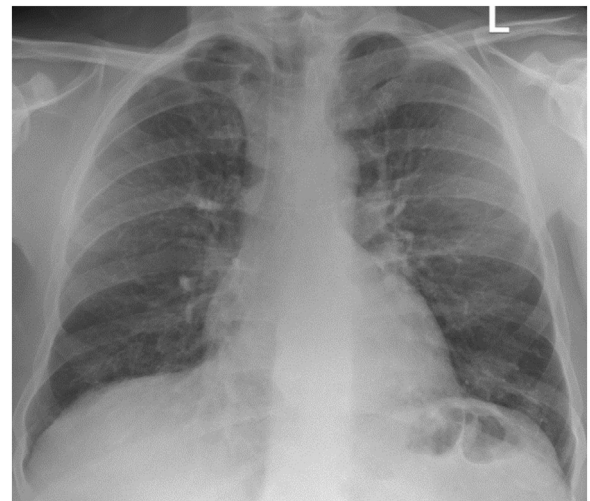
Posterior anterior chest radiograph demonstrating diffuse alveolar infiltrates bilaterally.
